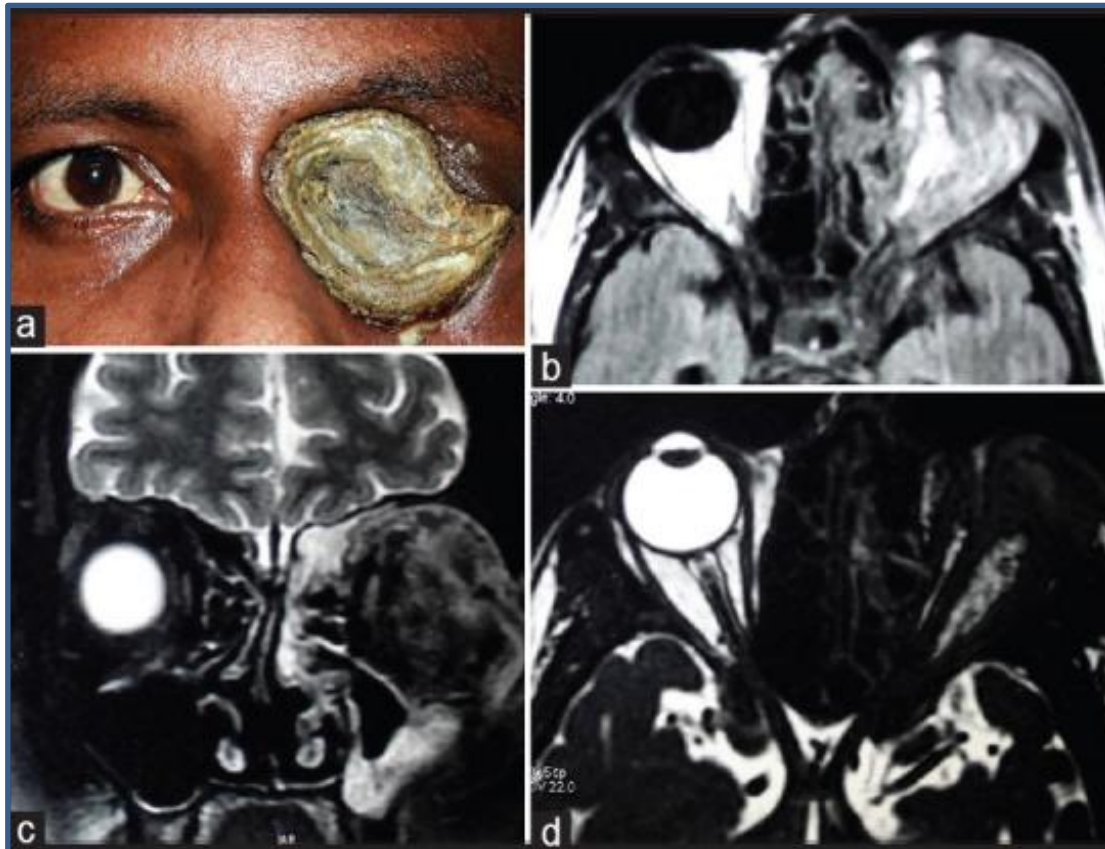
(a) Eschar covering the left periocular skin, as seen in a clinical picture. Ocular structures and eyelids blend., (b) Magnetic resonance imaging (MRI) scan with a T1-weighted axial section through the orbital midpoint. The mass in the left orbit is difficult to characterize since it is isointense. Superior orbital fissure and cavernous sinus extension is observed, (c) The maxillary sinus and orbit as shown on a T2 weighted coronal slice. The maxillary sinus mucosa has become thickened and opaque. Extraconal and intraconal space are filled by a diffuse, hypo- to iso-intense mass. The globe is unrecognisable, (d) Scanning the orbit with a T2 weighted image. The muscles surrounding the eyes have grown. Mixed intraconal and extraconal signal strength suggests a poorly defined mass invading orbital structures and fat ⁽⁹⁾.
